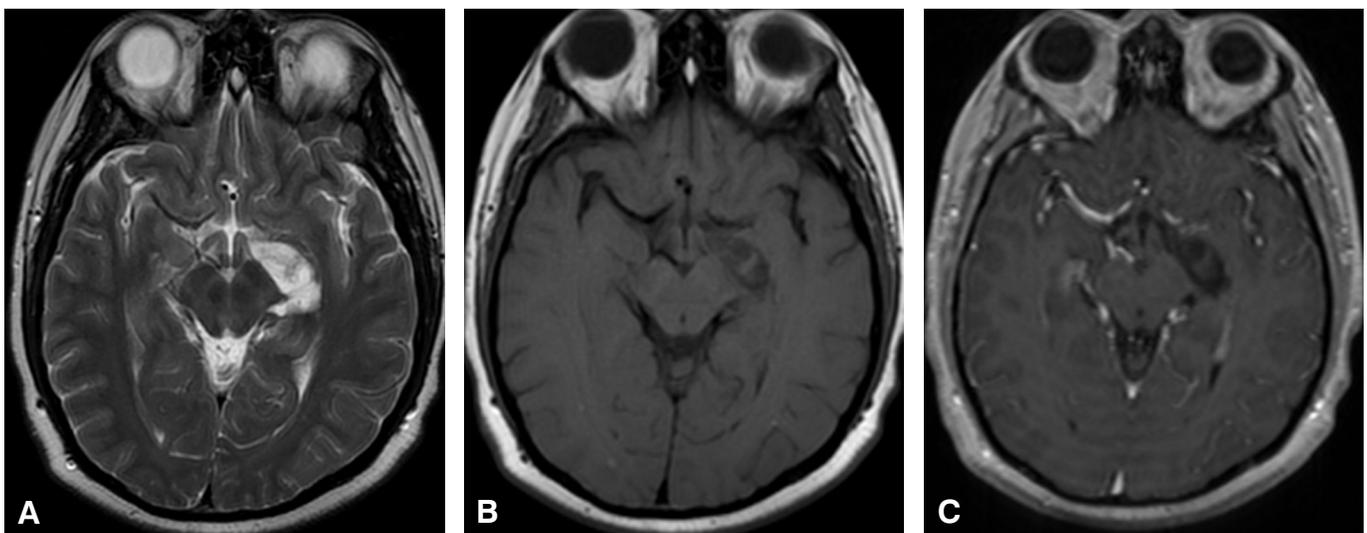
(A) Axial T2-weighted MR image shows a hyperintense lesion in the mesial temporal lobe. Axial T1-weighted MR images (B) with and (C) without contrast show a hypointense lesion that does not enhance.
